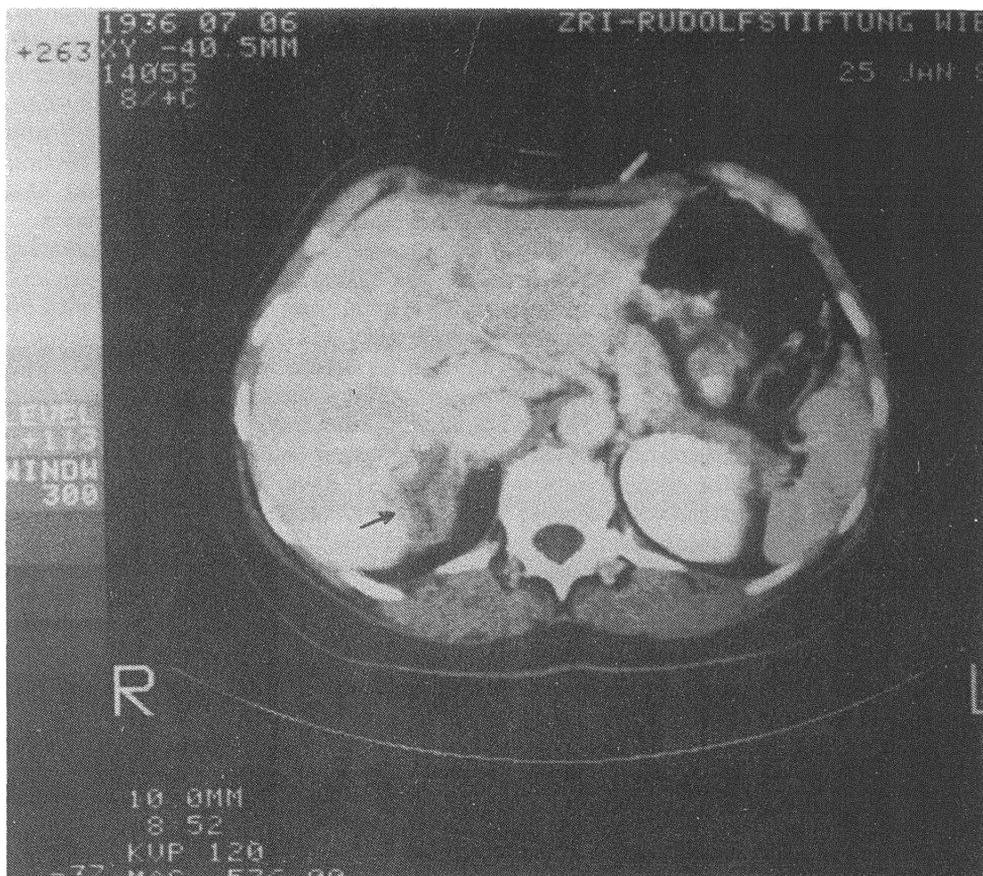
CT four months after the onset of chemotherapy
